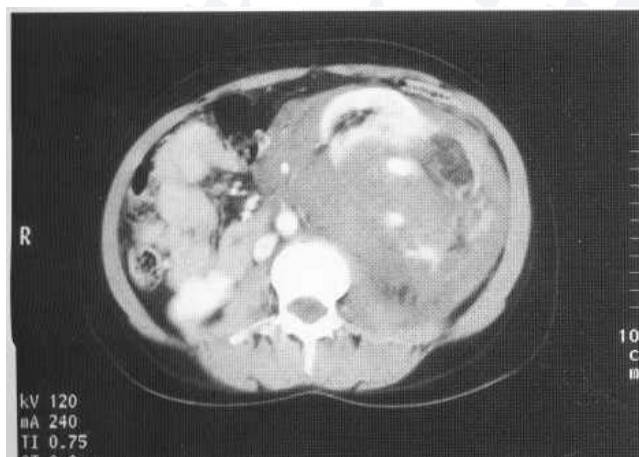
Left-sided angiomyolipoma with brisk haemorrhage, some of which is sufficiently acute to appear as ill-defined high-density areas on CT.
